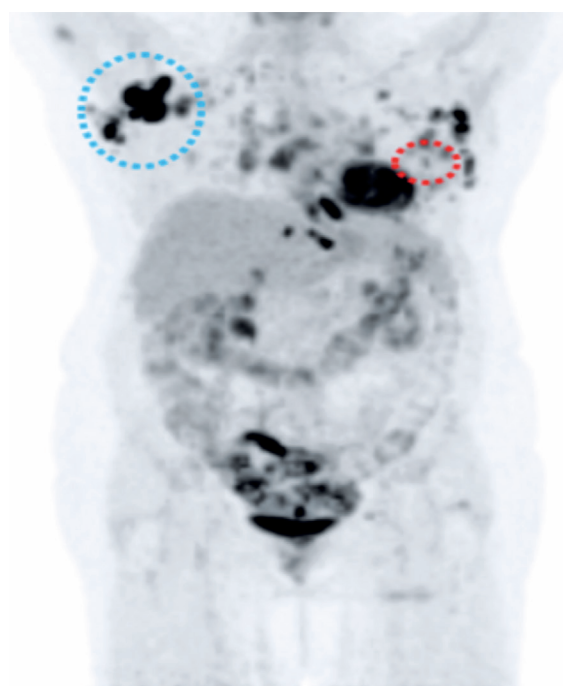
A coronal projection showing multiple suspicious lesions with intense FDG uptake, particularly evident in the right axillary lymphadenopathy and pulmonary nodules
